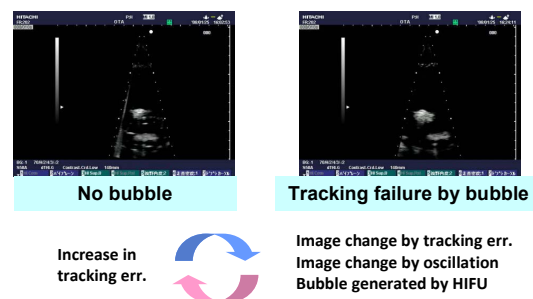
Problems in visual motion tracking by ultrasound images
